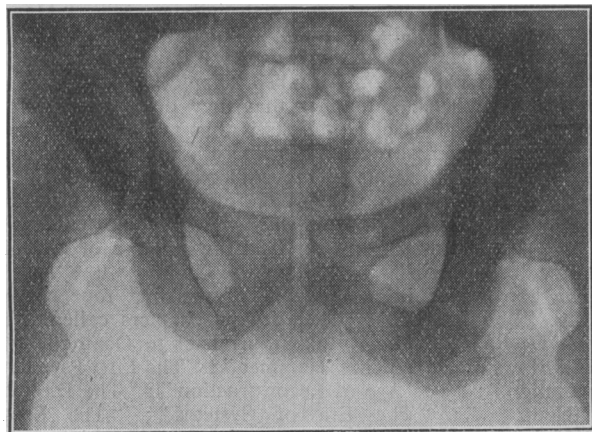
Radiograph showing position of the foreign body.
